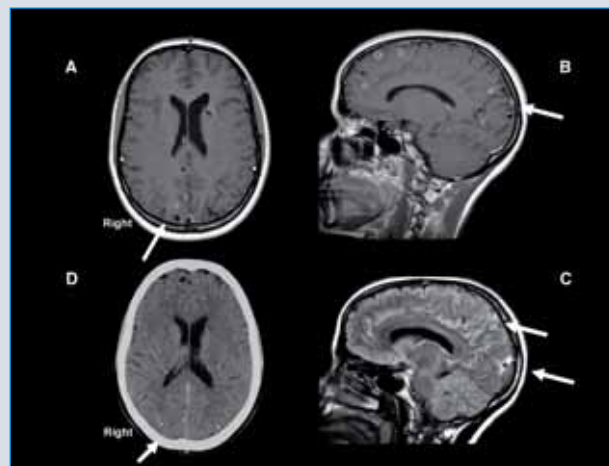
Neurocysticercosis. Multiple small parenchymal cystic lesions compatible of neurocysticercosis are shown. Stages of cysts were variable and included all stages from vesicular cysts (with scolex), to colloidal cysts and nodules (Figures 2A, B). A CT scan showed several calcified cysts ((Figure 2D). There were a large number of cysts in right mesial occipital cortex extending to right mesial occipito-parietal cortex (Figures 2B, C). These occipital and occipito-parietal cysts were surrounded by a prominent perilesional edema (Figure 2C) suggestive of active cysts.
